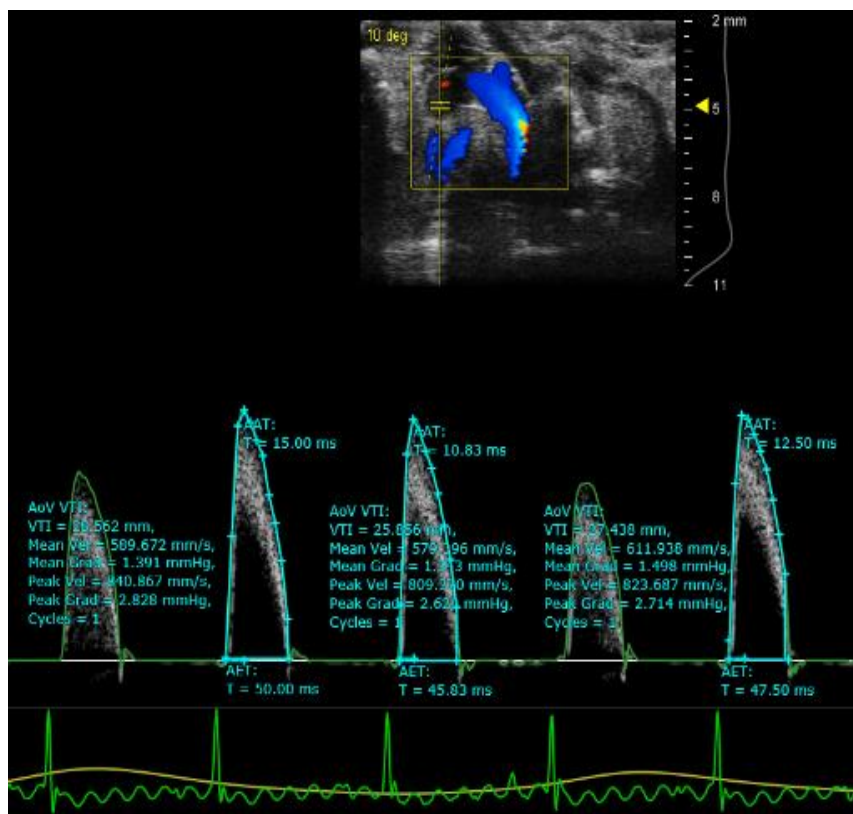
Aortic arch view, with pulse wave Doppler (PW) of the aortic flow.
